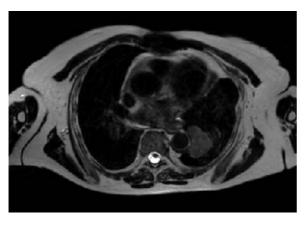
MRI of the thorax: locally advanced lung tumor, but exclusion of an infiltration into the thoracic aorta.
